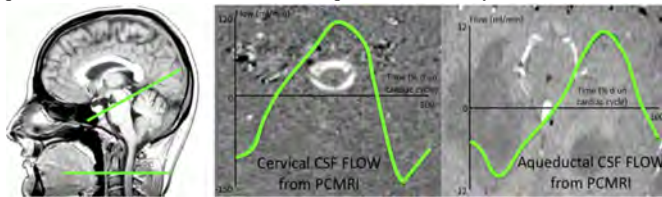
Dynamic analysis by phase contrast MRI
